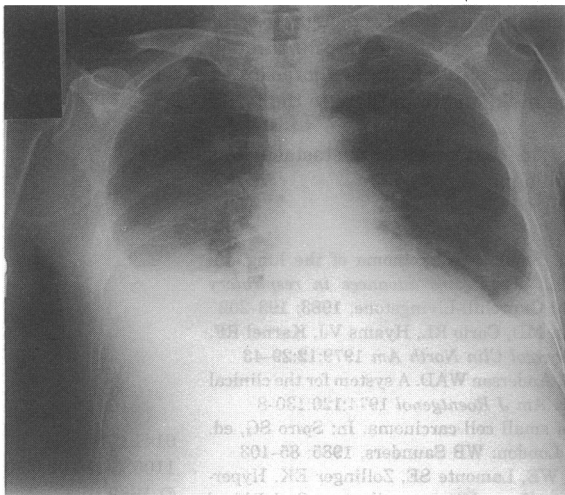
Chest radiograph revealing bilateral pleural effusions containing bile - a bilateral bilothorax
